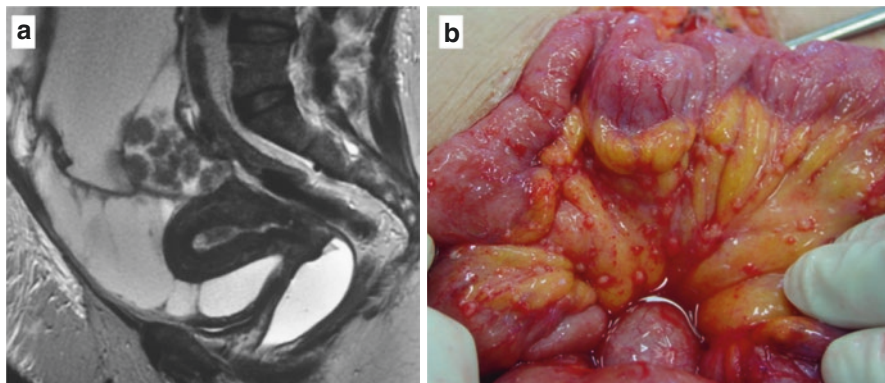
(a) Pelvic magnetic resonance imaging showing an ovarian tumor with solid component (arrow). (b) Intraoperative aspect of carcinomatosis with implants in the small bowel and mesentery
